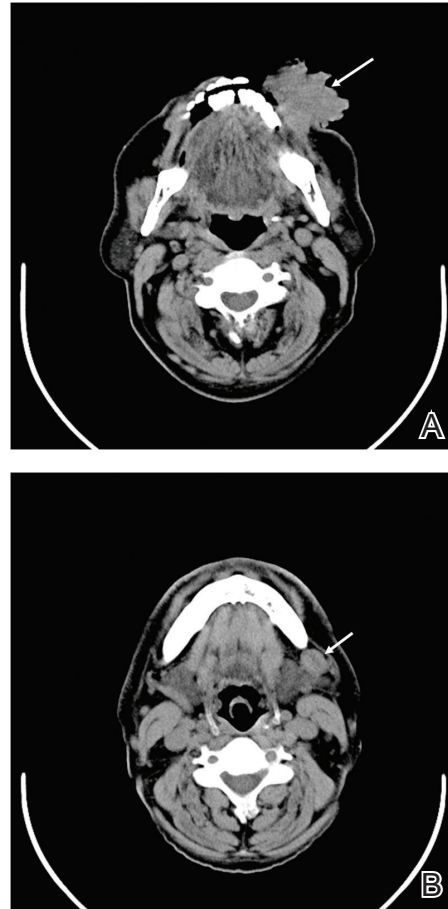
Computed tomography revealed a large soft-tissue mass involving the left buccal mucosa, overlying soft tissues and skin with exophytic ulceropolypoidal surface (white arrow)(A). An enlarged lymph node was noted in the left submandibular region (white arrow)(B).
